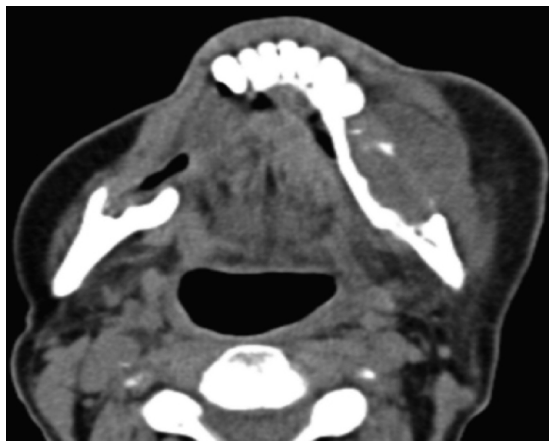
Axial CT scan showing soft tissue mass occupying the right body of the mandible with destruction of the mandibular cortex, as well as a rupture of the basic buccal cortical.
